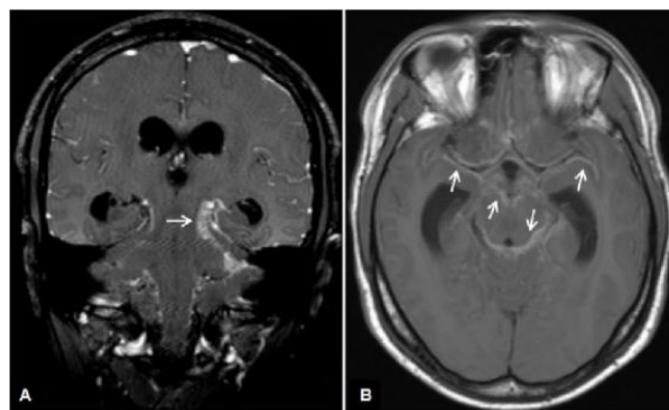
Brain MRI T1 with gadolinium contrast images. (A) Coronal view and (B) Axial view: meningeal enhancement (white arrows).
